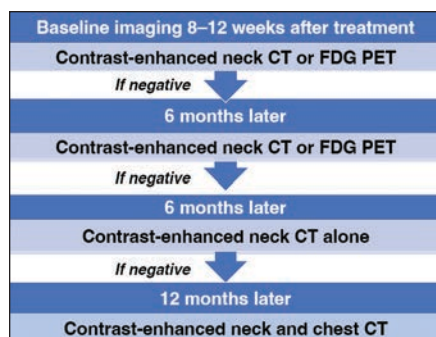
Algorithm for surveillance imaging after treatment of head and neck cancer, based on Neck Imaging Reporting and Data System. Algorithm entails baseline contrast-enhanced FDG PET/CT performed 8–12 weeks after treatment, followed by imaging performed at 6- to 12-month intervals for 24 months in absence of recurrence. Additional imaging would be performed if surveillance examinations show suspicious findings.
